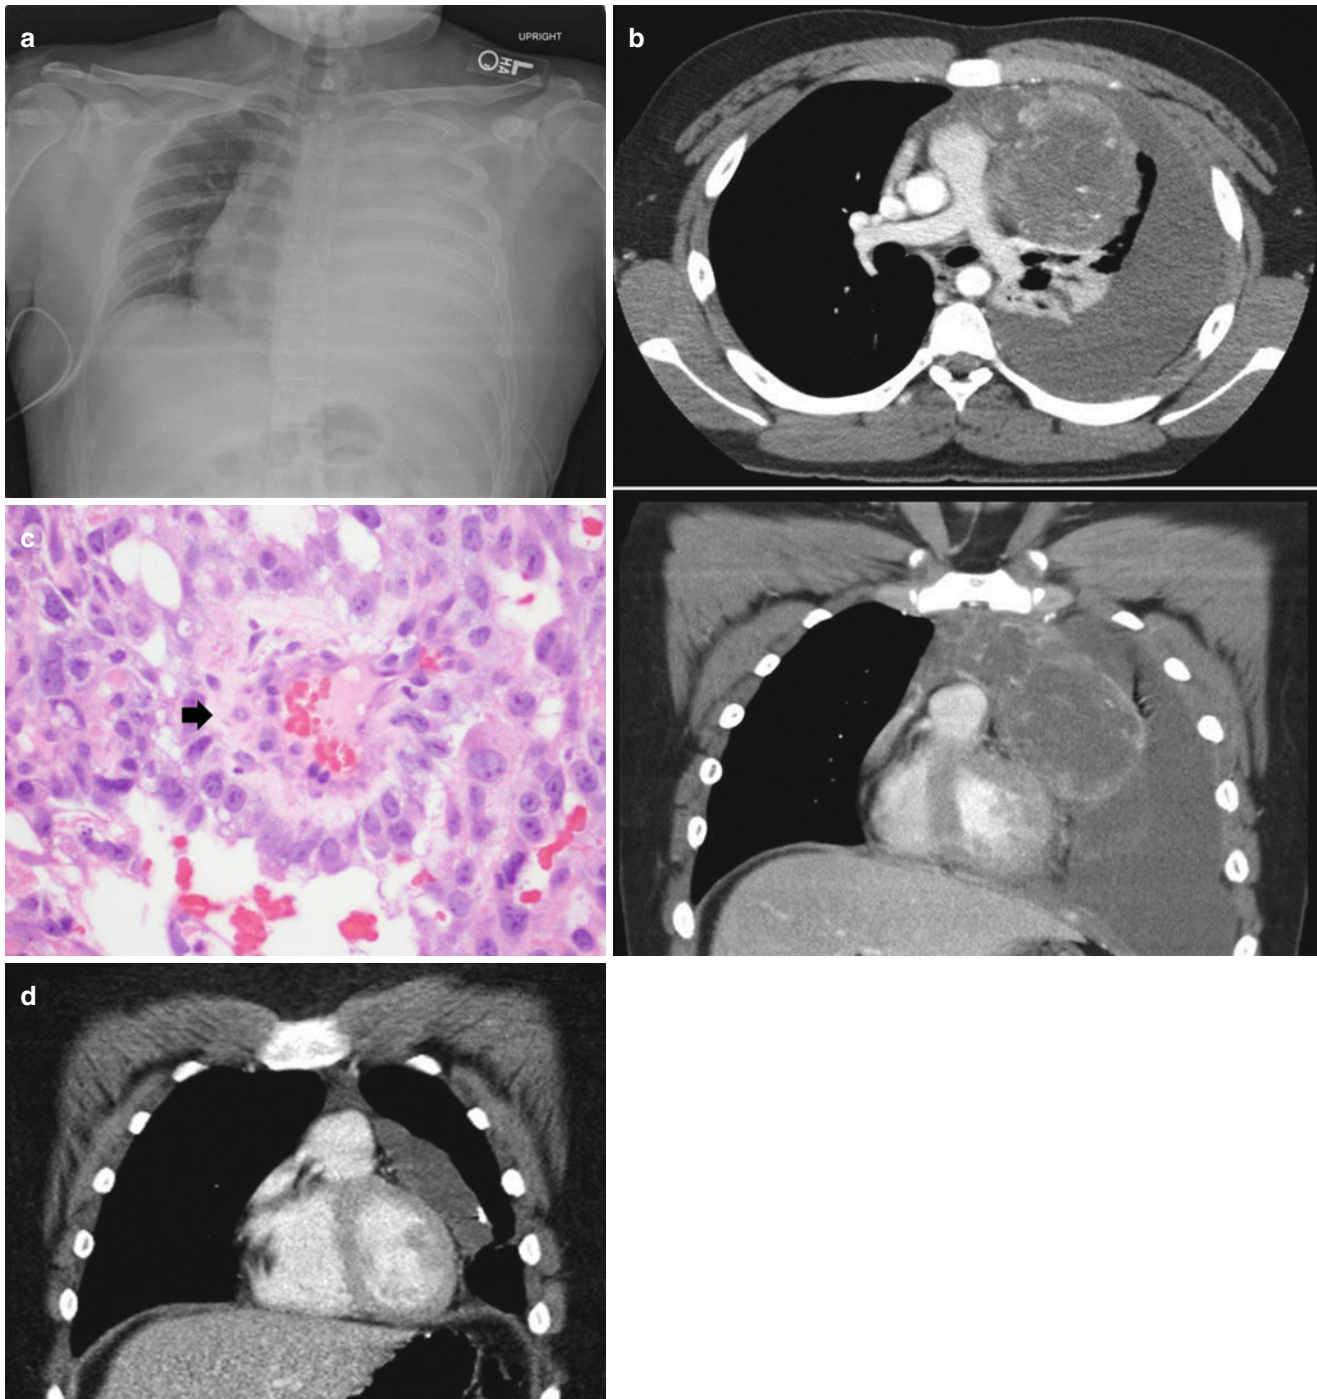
(a) Chest radiograph of a 17 year old male with anterior mediastinal mass and left hemothorax presenting with respiratory distress. (b) CT scan demonstrating the large anterior mediastinal mass with increased vascularity and associated hemothorax. The airway is patent but the mass is compressing on the pulmonary artery and left atrium. The patient had a chest tube placed which drained mostly sanguinous fluid output; cytology was not diagnostic. After multidisciplinary discussion, thoracoscopic decortication and biopsy were done under general anesthesia. The patient received
